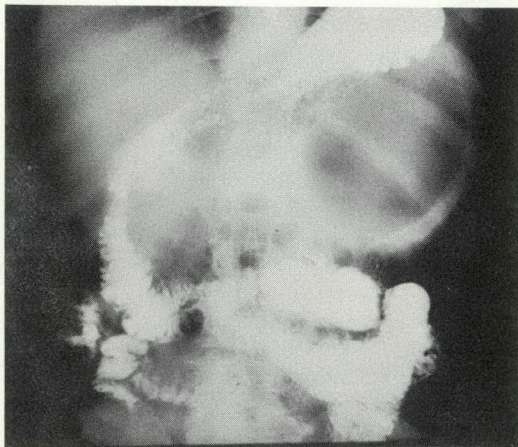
Upper gastrointestinal radiograph showing air-filled cyst in left upper quadrant.
